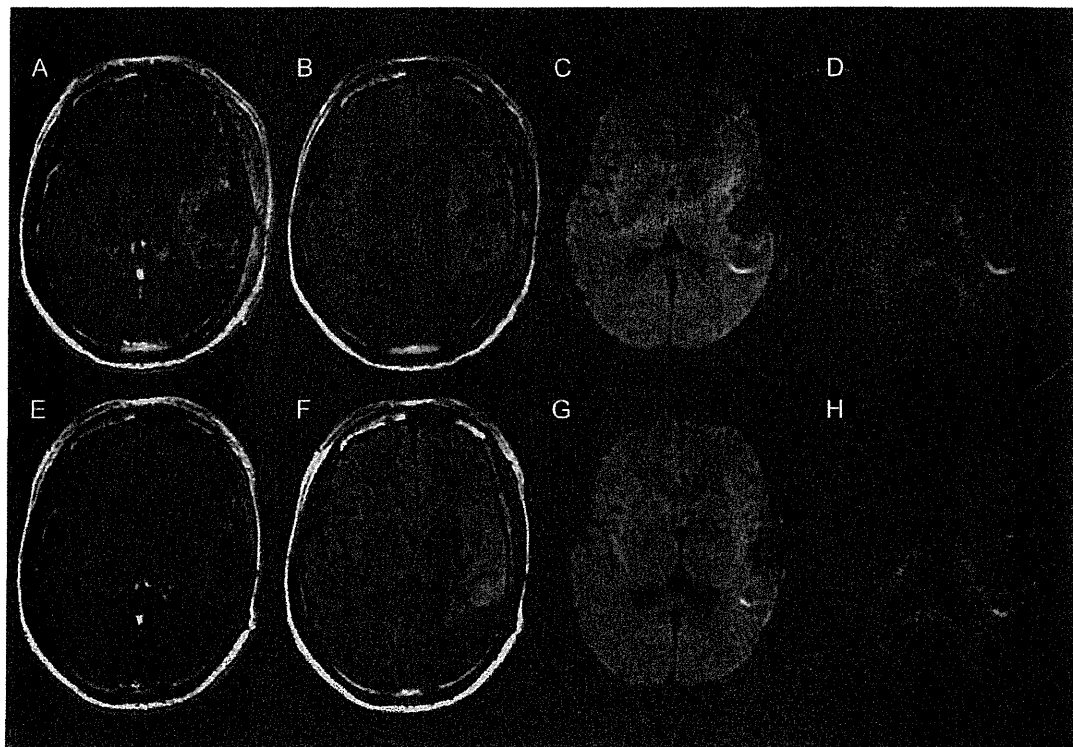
This 37-year-old man with glioblastoma underwent radical surgery and radiotherapy with concomitant and adjuvant chemotherapy with temozolomide. Gadolinium (Gd)-enhanced T1-weighted- (A) and FLAIR images (B), DW images at $b=1000$ s/mm² (DWI₁₀₀₀) (C) and at $b=4000$ DWI (DWI₄₀₀₀) (D) were acquired before treatment with bevacizumab. Gd-enhanced T1-weighted images showed a marked decrease in the enhanced lesion (E). On FLAIR images (F), DWI₁₀₀₀ (G), and DWI₄₀₀₀ (H) the high intensity area was decreased. At present, 6 months post-treatment, there has been no tumor recurrence and he continues to receive bevacizumab treatment.
